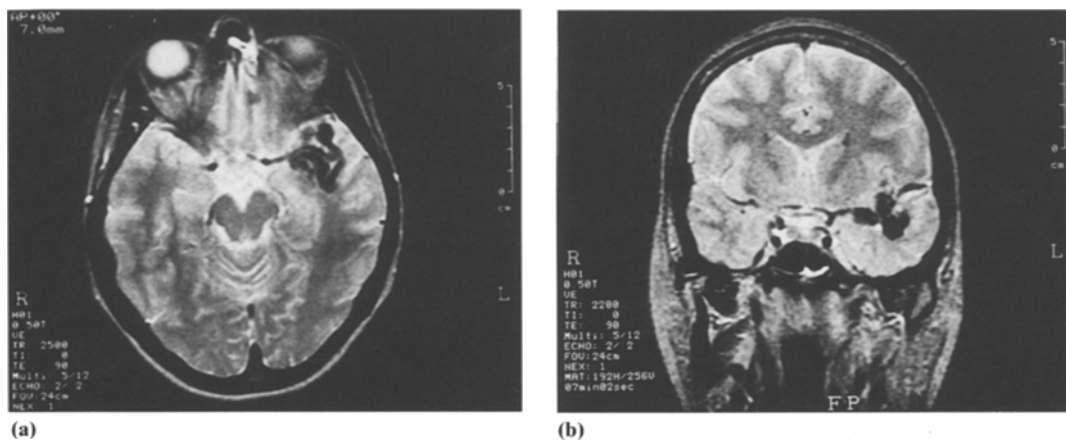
T2-weighted axial (a) and coronal (b) MR images, showing an irregular hypointens lesion located in the left temporal lobe.
